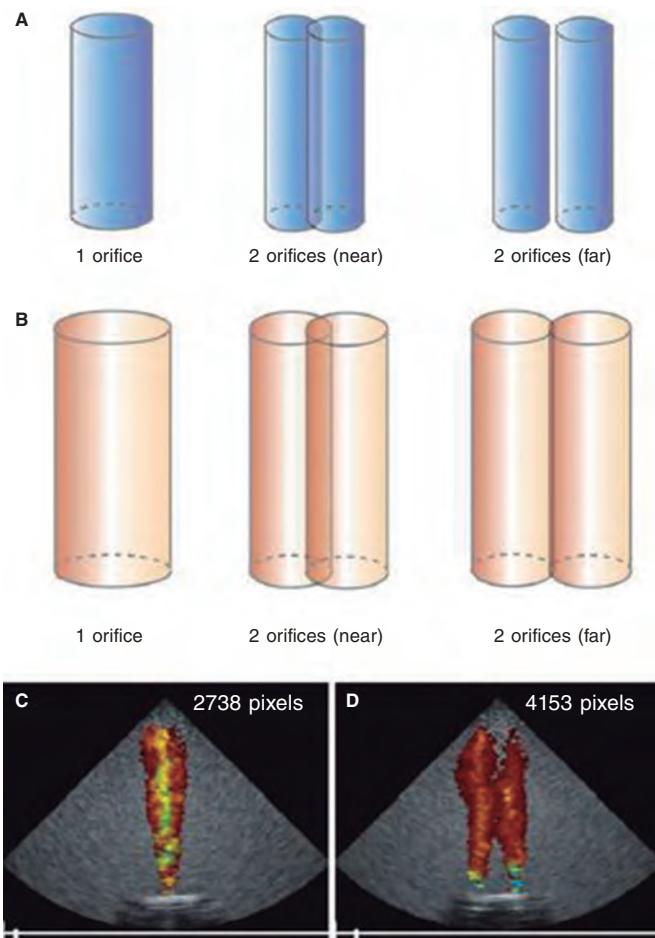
Impact of flow dynamics in the color Doppler jet area. The regurgitant volume from the ventricle towards the atrium creates interphase velocity between the former and atrial blood that generates surface shear stress where blood vortices that take more blood around them are produced. The color Doppler jet area looks magnified compared to the early regurgitant volume. A and B show that when the same regurgitant volume passes through 2 nearby or distant orifices with respect to one another, both jets merge due to the formation of vortices thus giving the impression of more severity. C and D show that for any given volume (eg, 10 mL), the number of pixels generated based on the number of orifices duplicates. Reproduced with permission from Lin et al.²⁰
